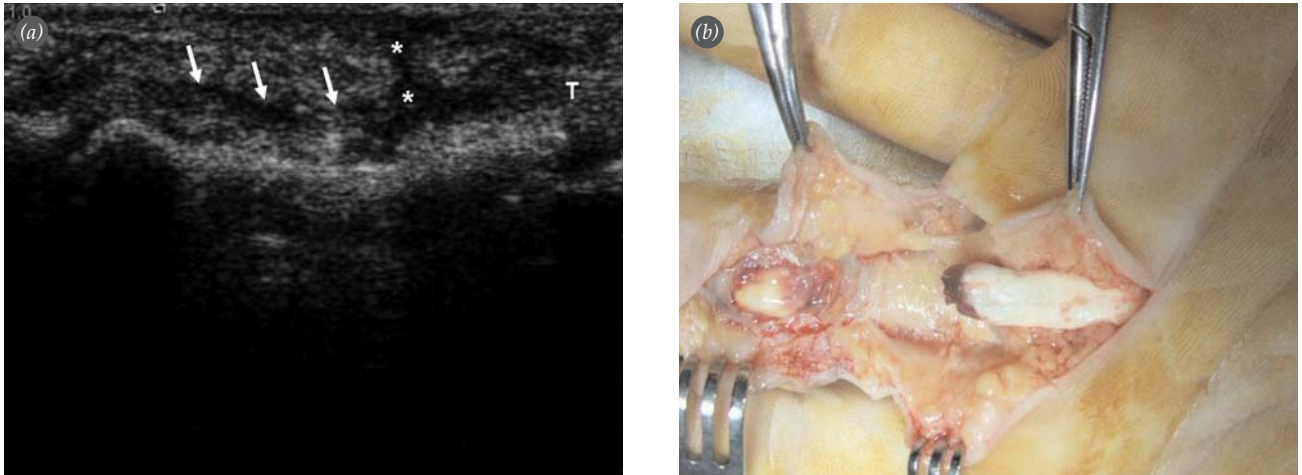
(a) Late ruptured flexor tendon in ultrasonography. The thickness of the tendon is narrowed (arrows) with a loss of the fibrillar pattern. Asterisks show rupture site. T: Retracted proximal end of the tendon. (b) Surgical confirmation of tendon rupture.
